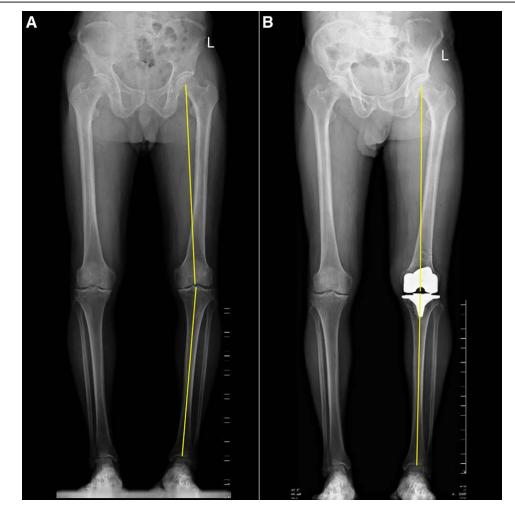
Radiographs demonstrating measurement of the overall lower extremity mechanical alignment both preoperatively (A), and after total knee arthroplasty (B). In this patient, the preoperative alignment was 8.3°, which was corrected to 0.6° postoperatively.
